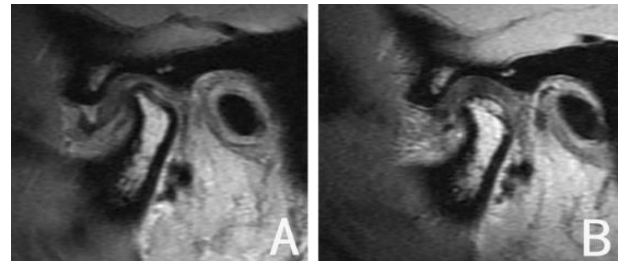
The condition of DDWR within TMJ complex before treatment, viewed using MRI; B TMJ complex after treatment with occlusal splint. Bone apposition can be seen in posterosuperior region of the condyle and the formation of retrodiscal fibrosis within the retrodiscal tissue.⁶
